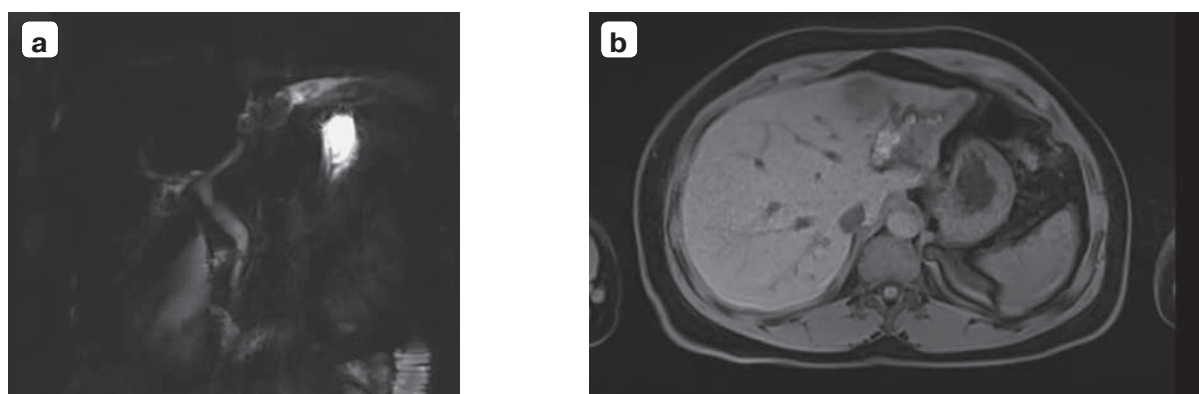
Image of biliary stricture in imaging: a – magnetic resonance cholangiopancreatography (MRCP); b – magnetic resonance imaging (MRI) axial.
